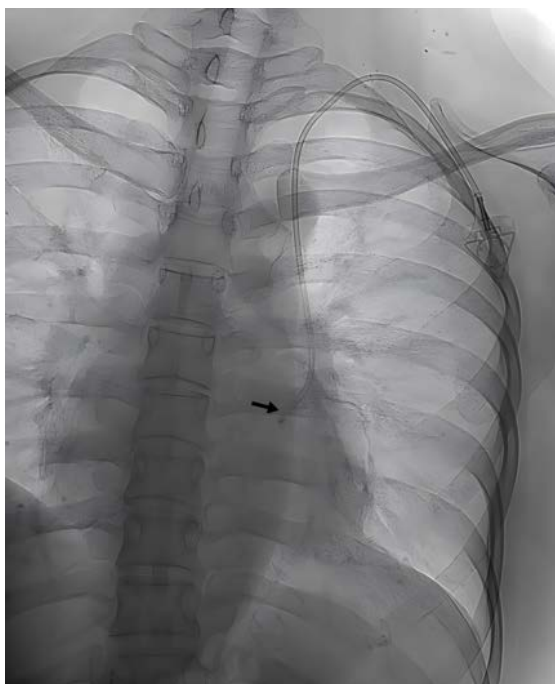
Post-procedural radiograph confirms the catheter tip (arrow) positioned at the level of the 7th posterior rib following venous access port implantation.
